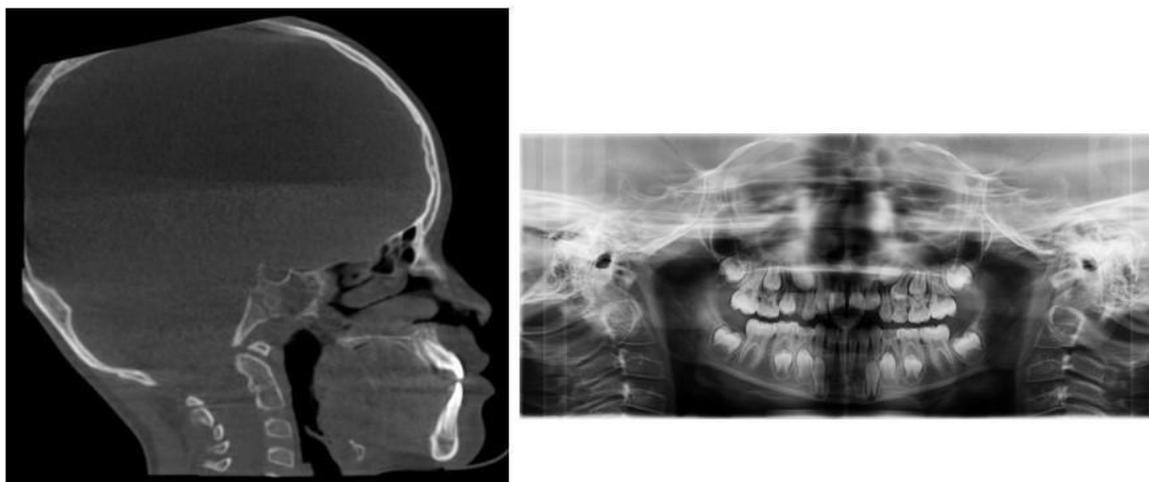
Post-facemask radiographs
